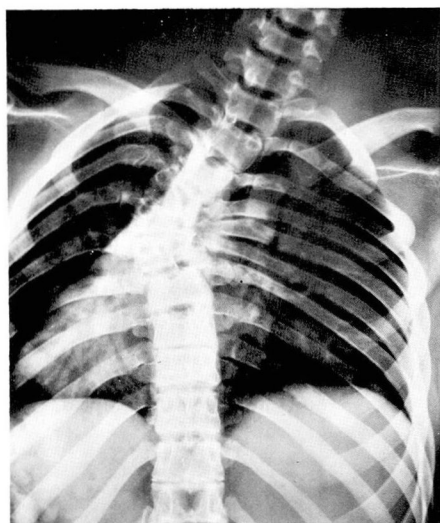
Case 1. X-ray film showing severe scoliosis of the thoracic spine.
